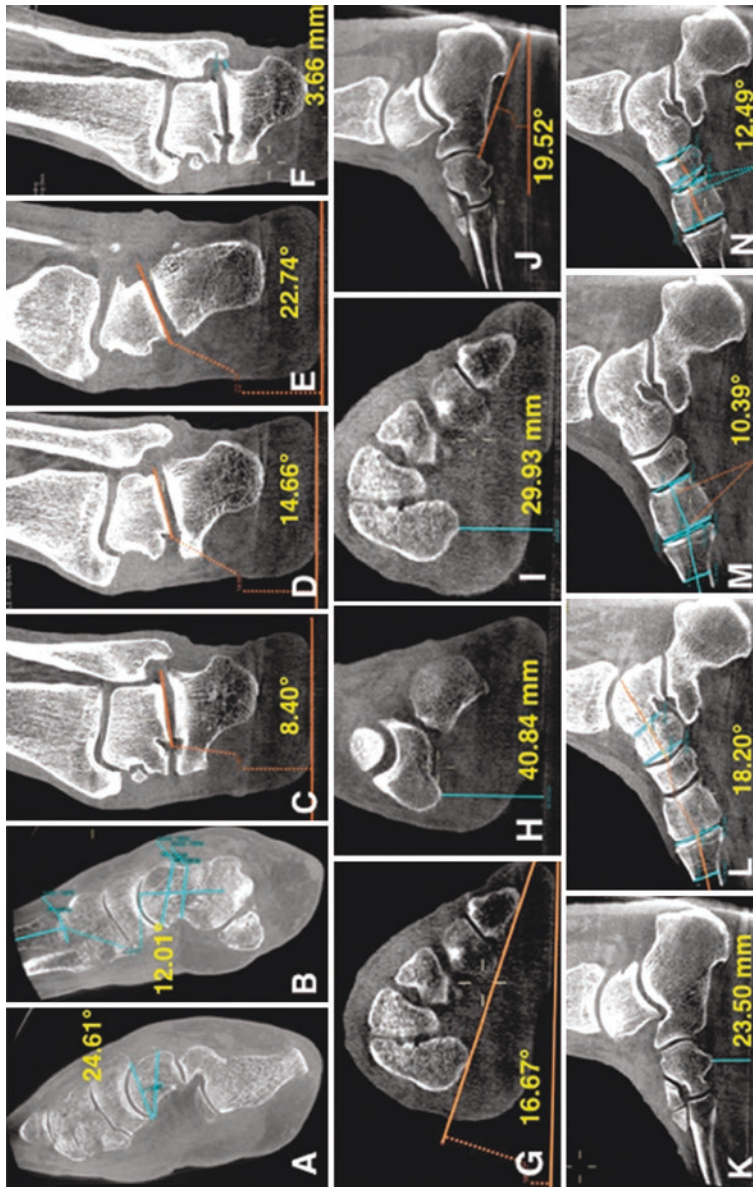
Examples of measurements performed by 3 readers in 19 patients with adult-acquired flatfoot deformity using weight bearing computed tomography. (a) Talonavicular coverage angle. (b) Talus-first metatarsal angle (axial plane). (c) Subtalar horizontal angle, 75% (posterior). (d) Subtalar horizontal angle, 50% (midpoint). (e) Subtalar horizontal angle, 25% (anterior). (f) Calcaneal-tilt angle. (g) Forefoot arch angle. (h) Navicular to floor distance. (i) Medial cuneiform to floor distance. (j) Calcaneal inclination angle. (k) Cuboid to floor distance. (l) Talus-first metatarsal angle (sagittal plane). (m) Medial cuneiform-first metatarsal angle. (n) Navicular-medial cuneiform angle
